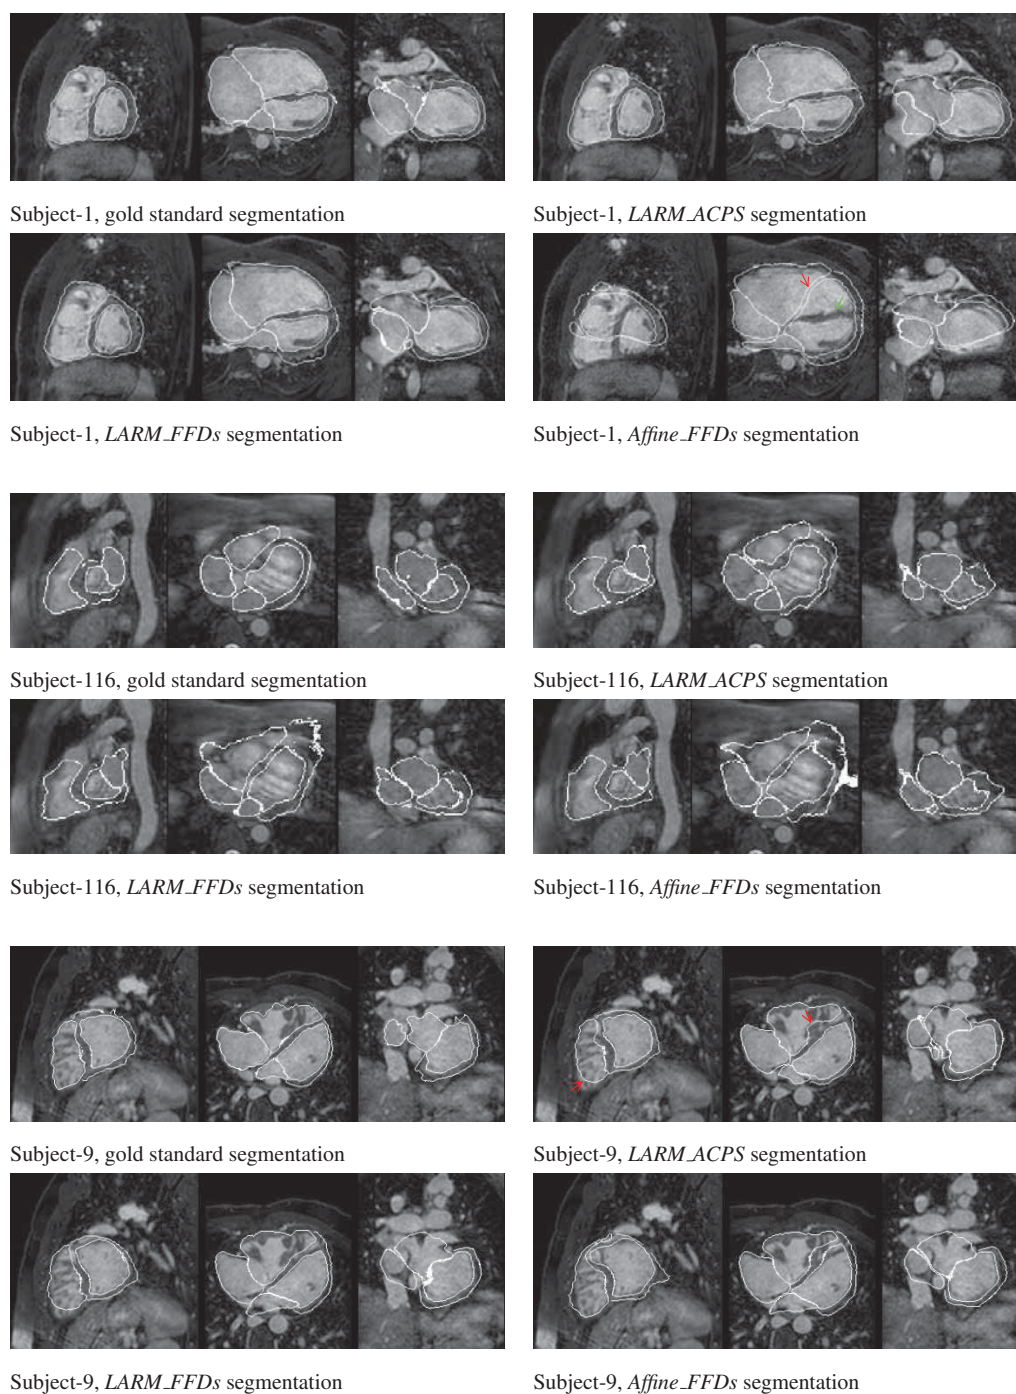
The worst cases by the three segmentation methods. Subject-1 is the worst case of the *Affine_FFDs*, subject-116 is the worst case of *LARM_FFDs*, and subject-9 is the worst case of *LARM_ACPS*. Images are displayed with delineated contour superimposed on the MR images, in sagittal, transverse, and coronal views. Subject-1 and subject-9 are pathological cases while subject-116 is a healthy case.
